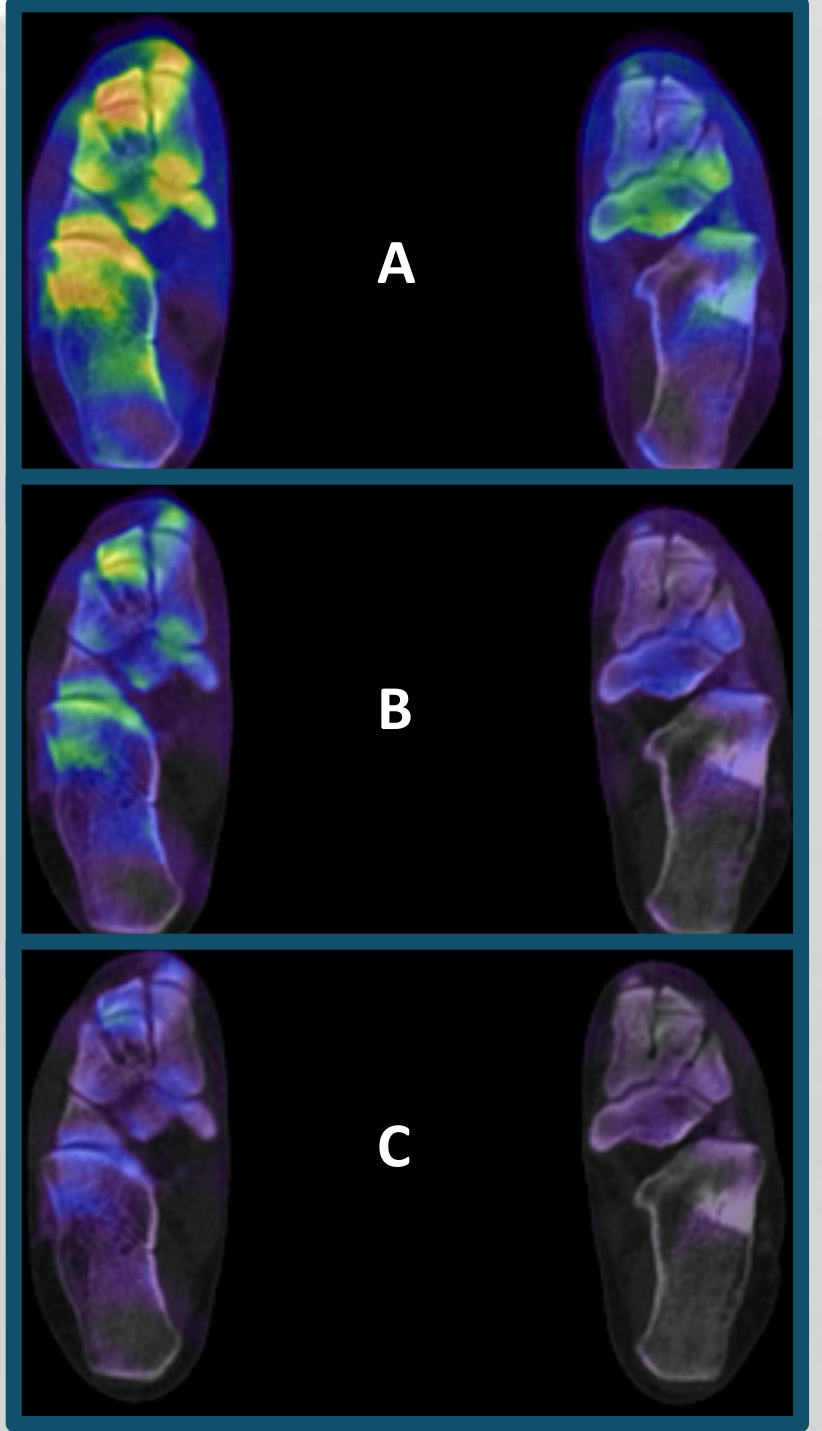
(above and right). Tc-HDP Bone scans (CASE 3). Planar images above: Blood flow (top row) and planar delayed images (bottom row). xSPECT/CT bone images (representative slice) shown right: (A) The default software window (SUV 0.2-9), (B) a user selected window (SUV 0.3-3.8) (C) our SUW foot (SUV 0.5-6 SUV).
